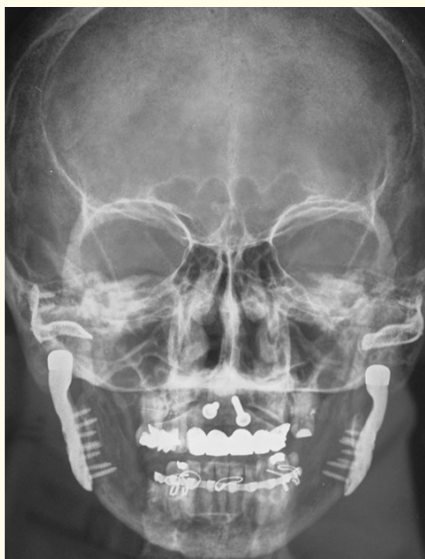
Radiograph that shows the bilateral prosthetic replacements in adequate position.*
